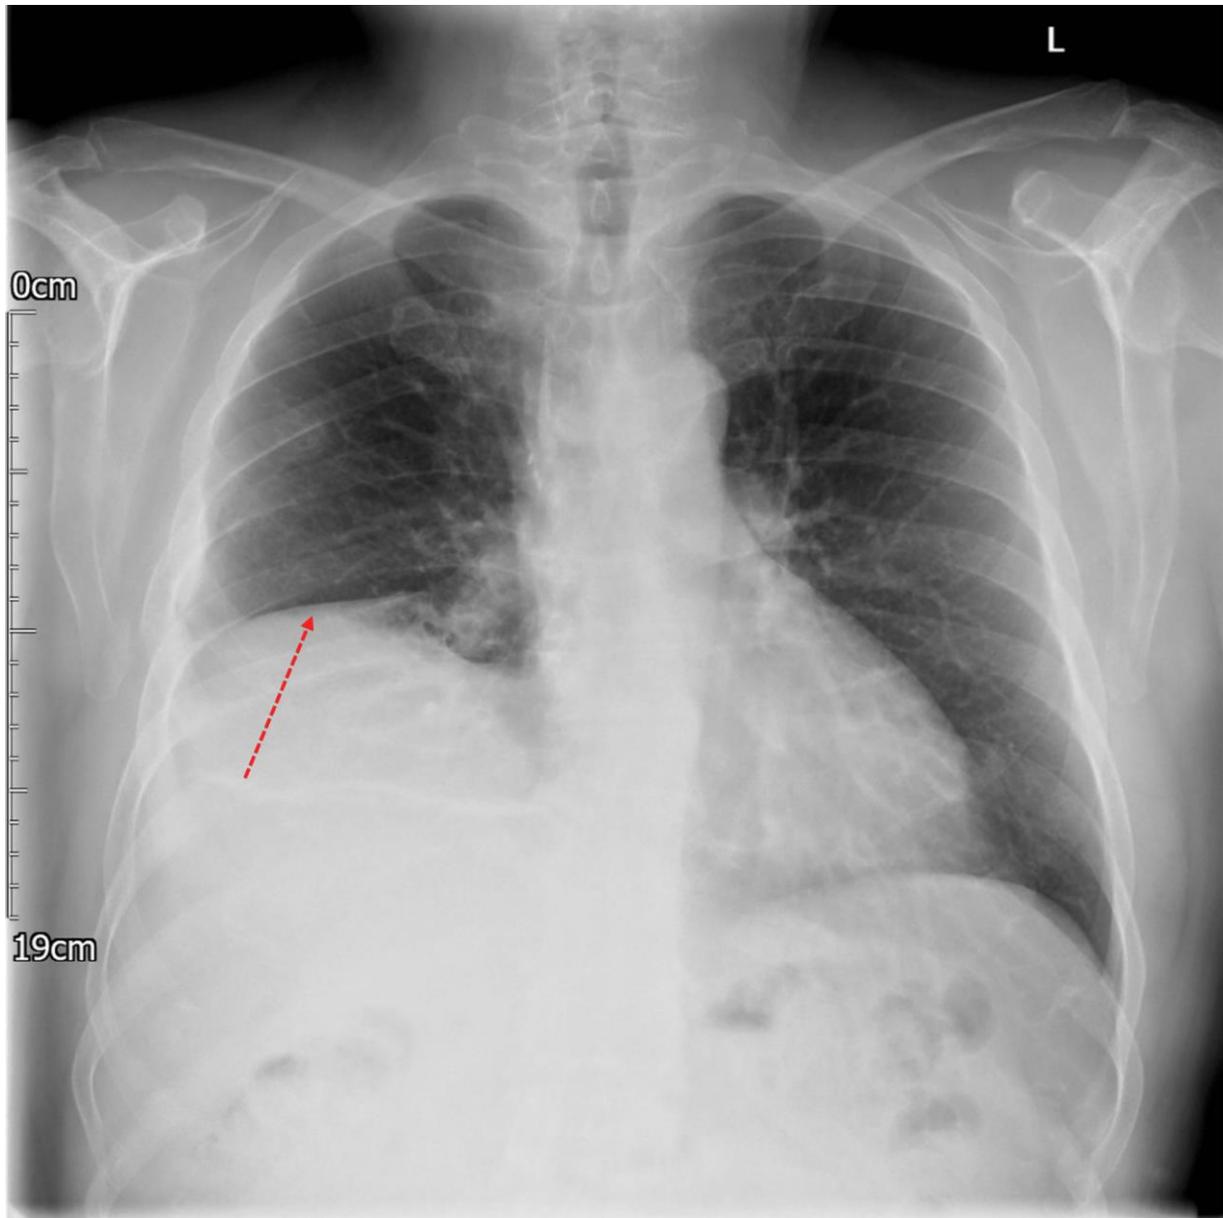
Chest X-ray performed on the third postoperative day showing clear lung field bilaterally. No obvious masses, nodules, consolidation or collapse visible. The right hemidiaphragm was elevated (red arrow).
